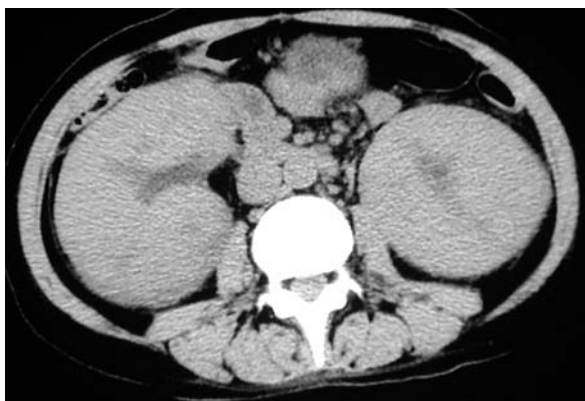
Acute lymphoblastic leukemia in a 48-year-old woman who relapsed after bone marrow transplantation. Axial unenhanced CT scan of the abdomen shows bilateral diffuse renal enlargement by tissue isodense to muscle attenuation. Note para-aortic lymphadenopathy.
